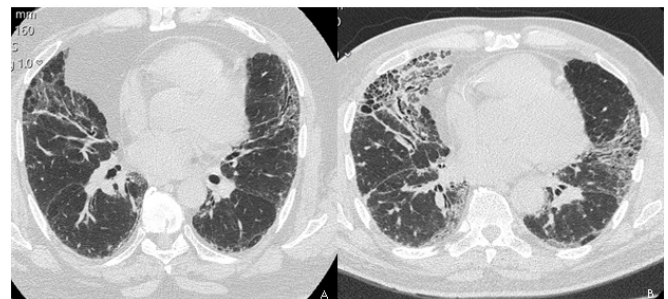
A: Chest CT image before the diagnostic surgery, showed peripheral ground glass areas with a peribronchovascular distribution, subpleural reticulation, traction bronchiectasis on the left lingular segment with a lower lobe predominance of the lesions, which was consistent with a probable UIP pattern B: Chest CT image after four years from diagnostic surgery, shows remarkable progression in findings consistent with IPF.
